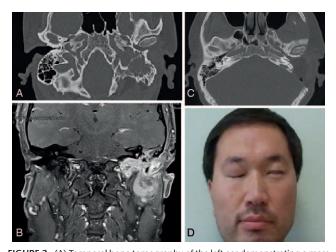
(A) Temporal bone tomography of the left ear demonstrating a mass in the mastoid portion of the temporal bone. (B) T1-weighted magnetic resonance imaging with contrast enhancement on coronal view demonstrates mastoid a mass extending deep into the parotid through the enlarged stylomastoid foramen. (C) Postoperative tomography revealed the reconstructed cavity with abdominal fat tissue. (D) Facial appearance of the patient 6 months later. Complete palpebral occlusion was achieved without involuntary mass movement.
